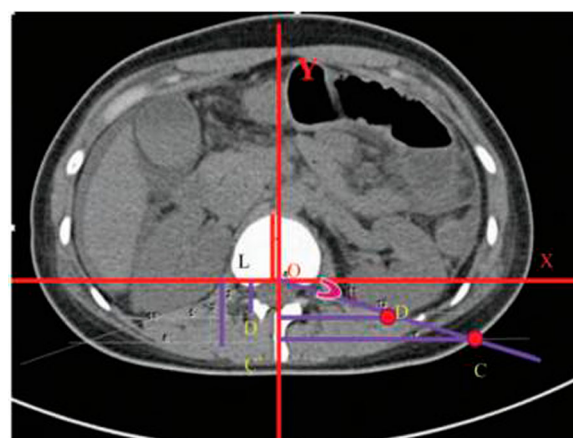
The graphic of CT cross section measurement. Vertebral sagittal diameter (L); The lowest point of the posterior renal fascia (OD'); critical point projection (OC'); critical angle (α); CT: computed tomography.
